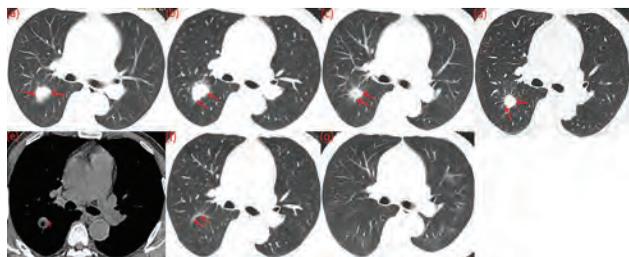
Lung CT in different periods.
